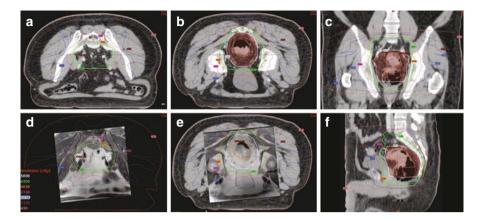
Treatment plan for neoadjuvant CRT of Stage II/III disease. In addition to the gross tumor volume (GTV) including suspicious or involved lymph nodes, the CTV A volume is electively treated. The GTV of the primary tumor is in orange and encompasses the entire rectum at the levels of disease. The planning target volume for the primary tumor is given in red. The total doses are 4500 cGy to the elective volumes (CTV A) and a simultaneous integrated boost of an additional 5 Gy to the gross disease. (a) Superior portion of treatment including the fused MRI (d). (b) Inferior portion of the treatment including the fused MRI (e). (c and d) Coronal and sagittal views of the treatment volume. The isodose lines are depicted in various colors with the legend at the bottom of the image
